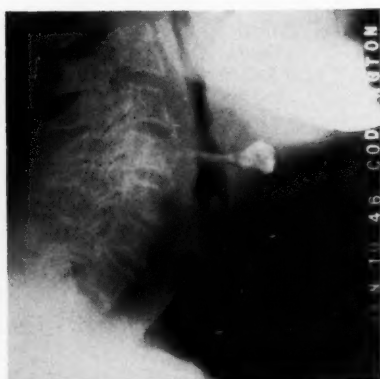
Lateral roentgenogram taken November 7, 1945 showing a shadow extending forward from the vertebral region. The upper margin of the bulge is at the top of the third cervical body. The apex of it is level with the middle of the fourth. The normal thickness of the tissue resumes at the level of the sixth. Barium mixture outlines the tumor mass.
